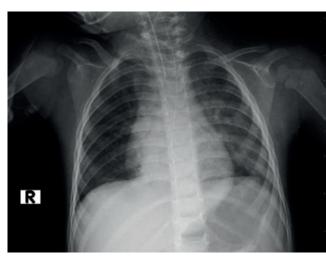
Posterior anterior chest X-ray after bronchoscopy
